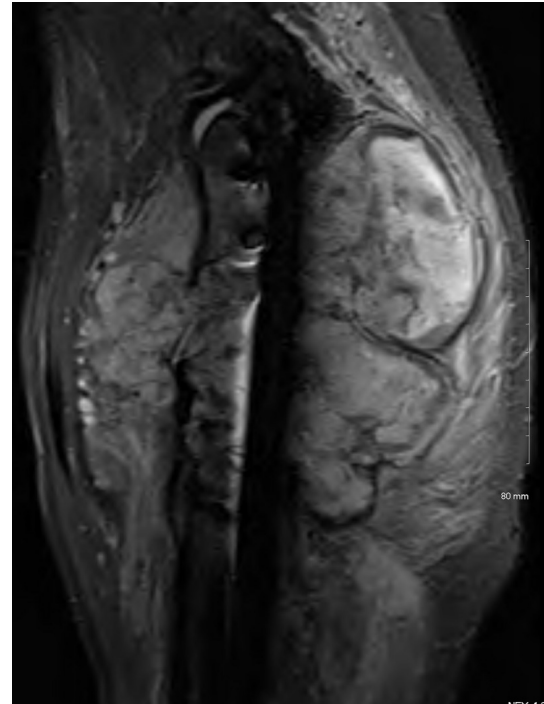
MRI (fat suppressed) of the left proximal femur, sagittal
